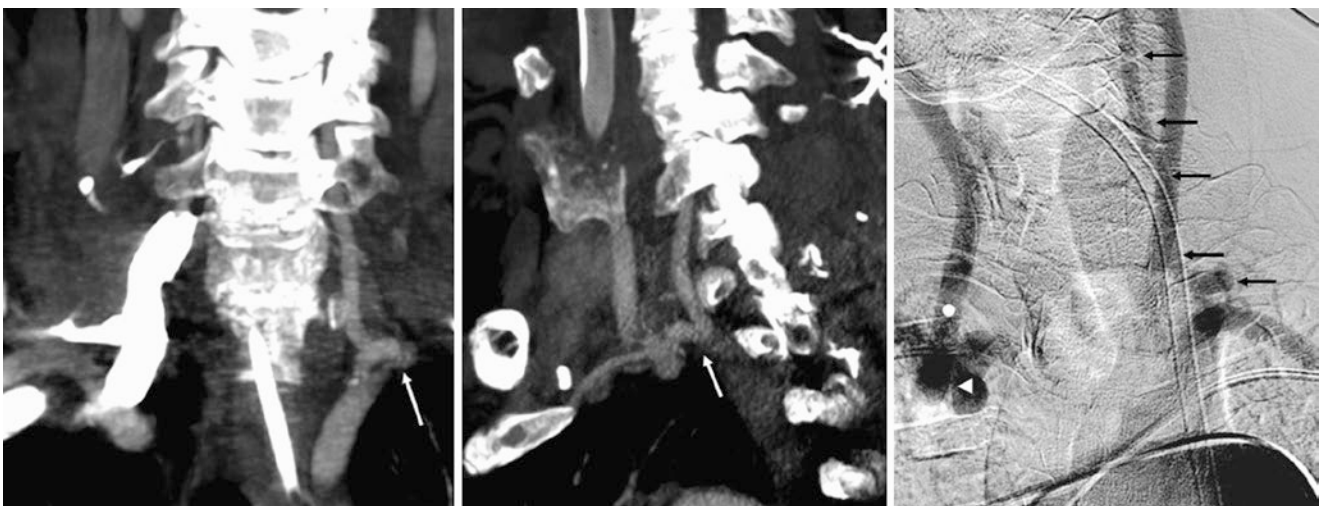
In a 76-year-old, CTA coronal (*left*) and sagittal (*middle*) 10 mm-thick MPRs and a DSA AP view (*right*) show a tortuous LVA (*arrows*), which was hard to catheterize. The right CCA (*white circle*) and RSCA origins (*left-facing arrowheads*) were tortuous, and the aorta was elongated
